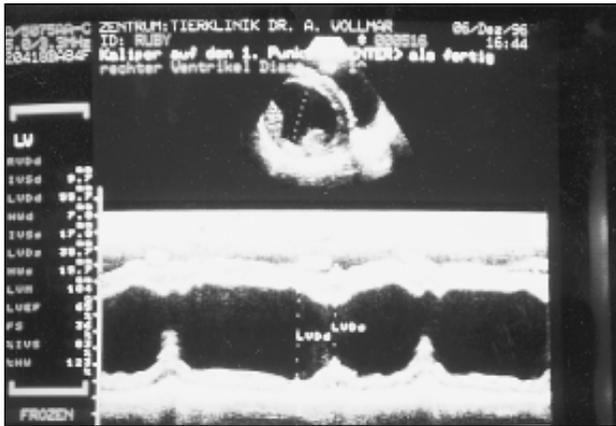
M-mode echocardiogram of a normal Irish wolfhound.
